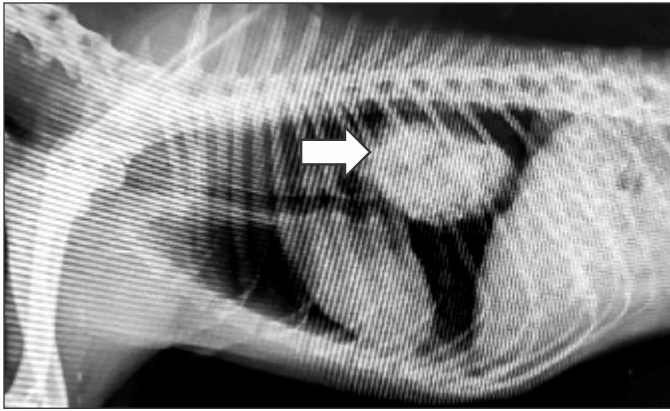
Plain radiography shows mild dilated, poorly defined radio-dense mass (71.4 × 44.2 mm) with irregular edges at the caudal thoracic region (Arrow)
